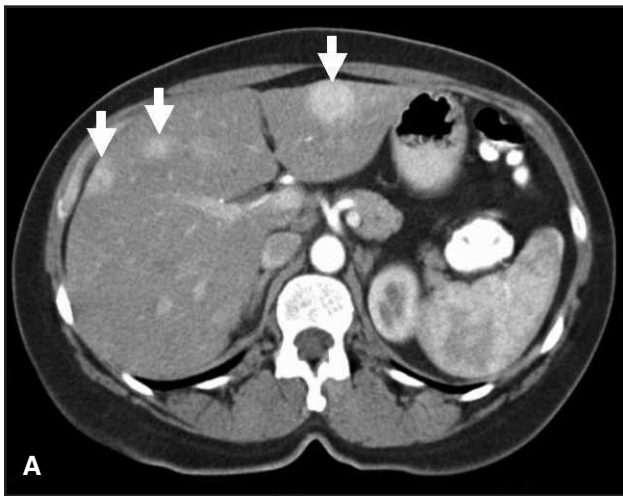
(A) Axial CT scan image shows hypervascular liver metastases (arrows) are well visualized during hepatic arterial phase of contrast administration in this patient with metastatic carcinoid tumor. (B) During portal venous phase there is wash out of contrast and poor visualization of the same lesions (arrows).
